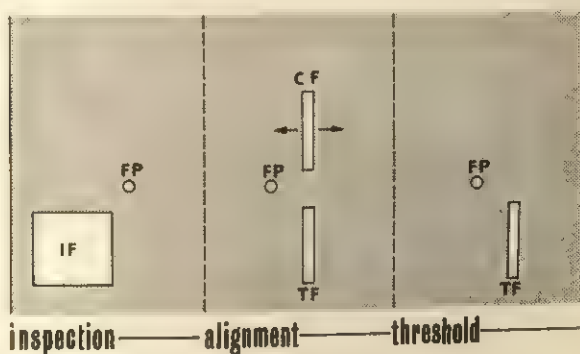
STIMULUS-PRESENTATIONS DURING INSPECTION AND DURING THE ALIGNMENT- AND THRESHOLD-TESTS
